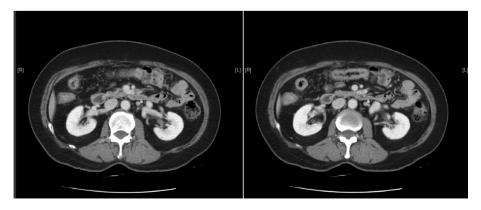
Axial chest CT images showing an aneurysm measuring 1.6 cm in diameter with mural thrombi in the distal left renal artery at bifurcation. CT = computed tomography.
